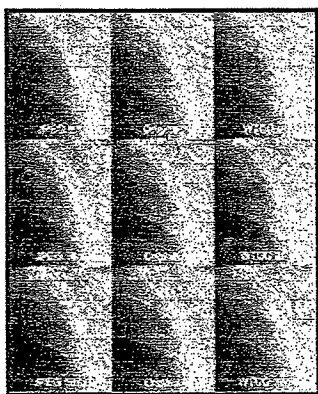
Compression artifacts. Compressed (JPEG, left column; WTCQ, right column) and noncompressed digital (middle column) posteroanterior radiographs of a selected region of interest show the effects of compression at ratios of 8:1 (top row), 16:1 (middle row), and 128:1 (bottom row). With both JPEG and WTCQ algorithms, the image compressed at 8:1 is indistinguishable from the original. At a compression ratio of 128:1, the manifestation of "tiling" or "blocking" artifacts on the JPEG image and blurring on the WTCQ image are readily apparent.
